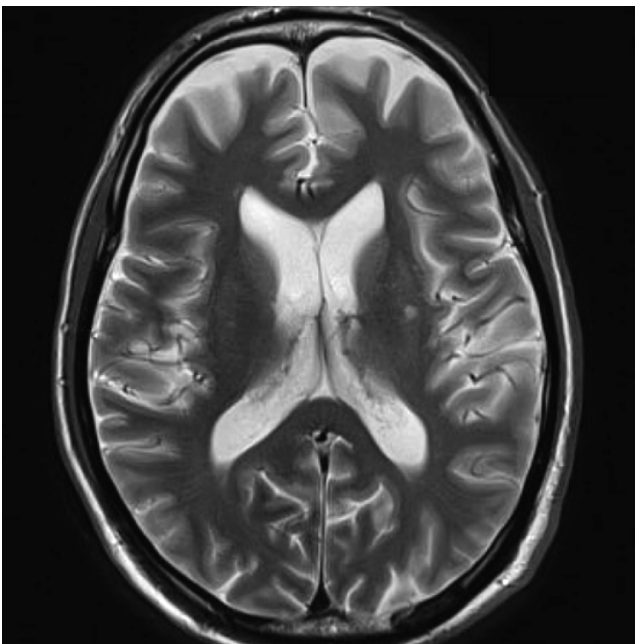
MRI T2-weighted sequence (axial view) showed T2 hyperintensity in the left lentiform nucleus.
